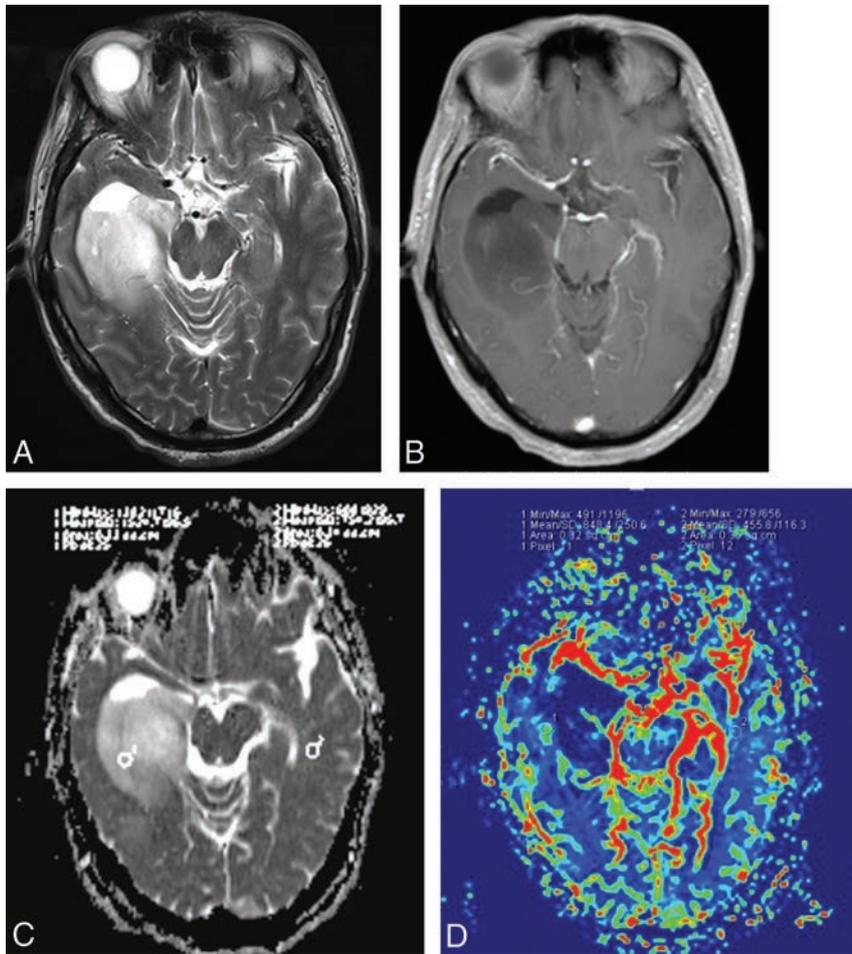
A 50-year-old man with an anaplastic astrocytoma with an *IDH* mutation. A, Axial T2WI demonstrates heterogeneous high signal intensity with sharp borders on the right temporal lobe. B, Contrast-enhanced axial T1-weighted image demonstrates a nonenhancing lesion in the right temporal region. C, A corresponding ADC map shows the tumor with an increased ADC value ($ADC_{\min} = 1.456 \times 10^{-3} \text{ mm}^2/\text{s}$, $rADC = 2.51$). D, Correlative color CBV image shows relatively low perfusion with the calculated $rCBV_{\max}$ of 1.86.
